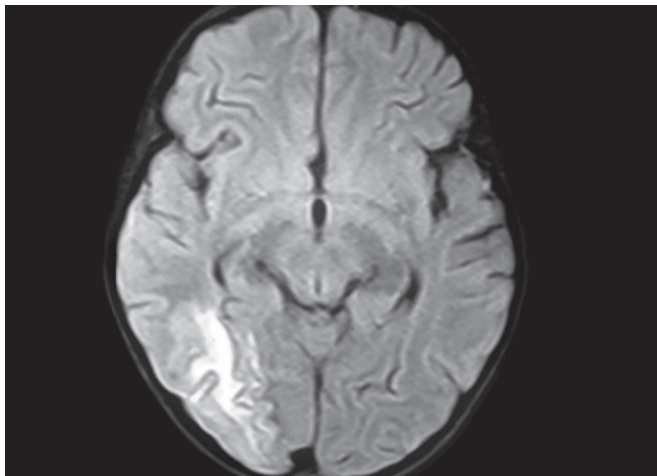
Axial FLAIR MRI demonstrating hyperintensities in right occipitotemporal cortex
